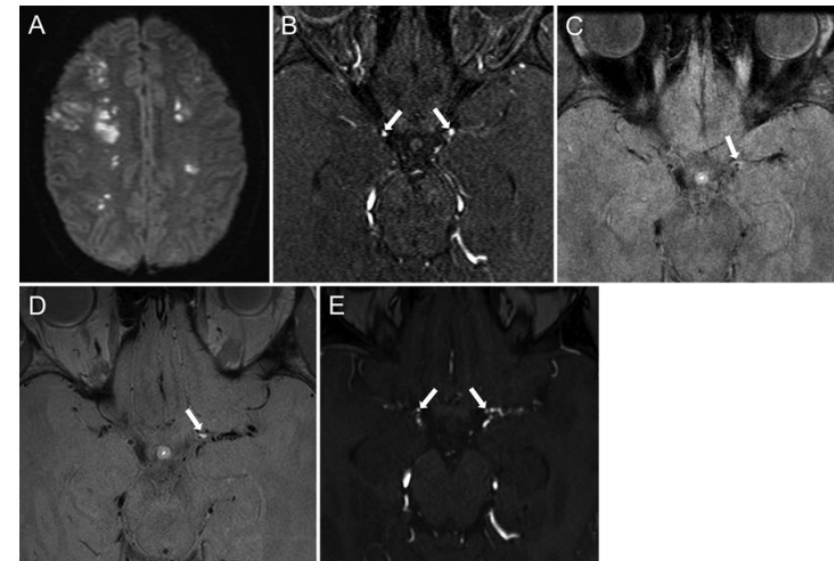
A: A 31-year-old woman presented with bilateral border zone infarcts on DWI. B: Three-dimensional TOF MR angiogram obtained at presentation, demonstrating moderate stenosis of the bilateral distal supraclinoid ICAs and proximal M₁ segments (arrows). C: Axial PD VWI study with gadolinium, demonstrating mild to moderate circumferential vessel wall enhancement of the left supraclinoid segment (arrow) and no appreciable enhancement of the right ICA vessel wall. D: Axial PD VWI study with gadolinium obtained at the 8-month follow-up, demonstrating increased enhancement of the stenotic left segment (arrow). E: Axial 3D-TOF MR angiogram demonstrating progressive stenosis of both the nonenhancing right and enhancing left stenotic segments (arrows). This case demonstrates that infarcts and progressive stenosis can be associated with either enhancing or nonenhancing segments and that vessel wall enhancement can evolve over time.
